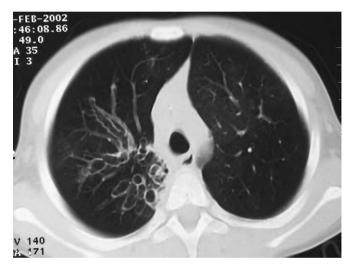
HRCT scan of a 4-year-old patient with postinfectious bronchiolitis obliterans and localized cystic bronchiectasis in the right lower lobe.
